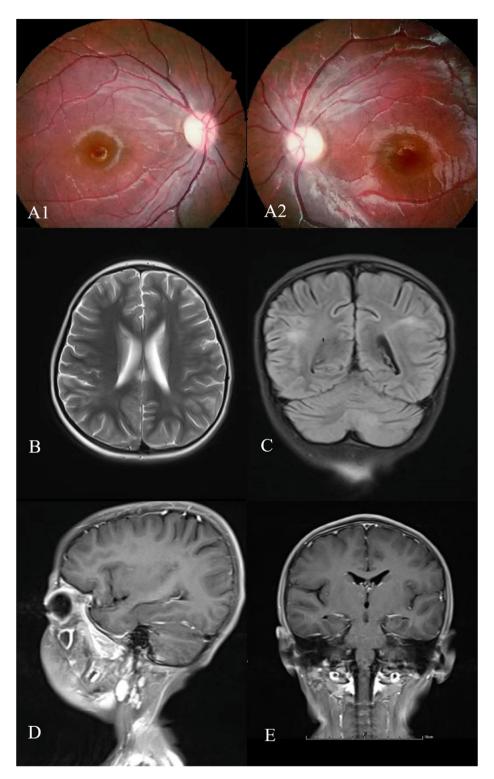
Fundus pictures showed right (A1) and left (A2) optic disc pale. The repeat brain MRI images $B \sim E$ showed subcortical structure, frontal lobe, parietal lobe, temporal lobe, occipital lobe, basal ganglia, thalamus and brainstem less signal abnormalities and no enhancement lesions in 1-month follow-up.
